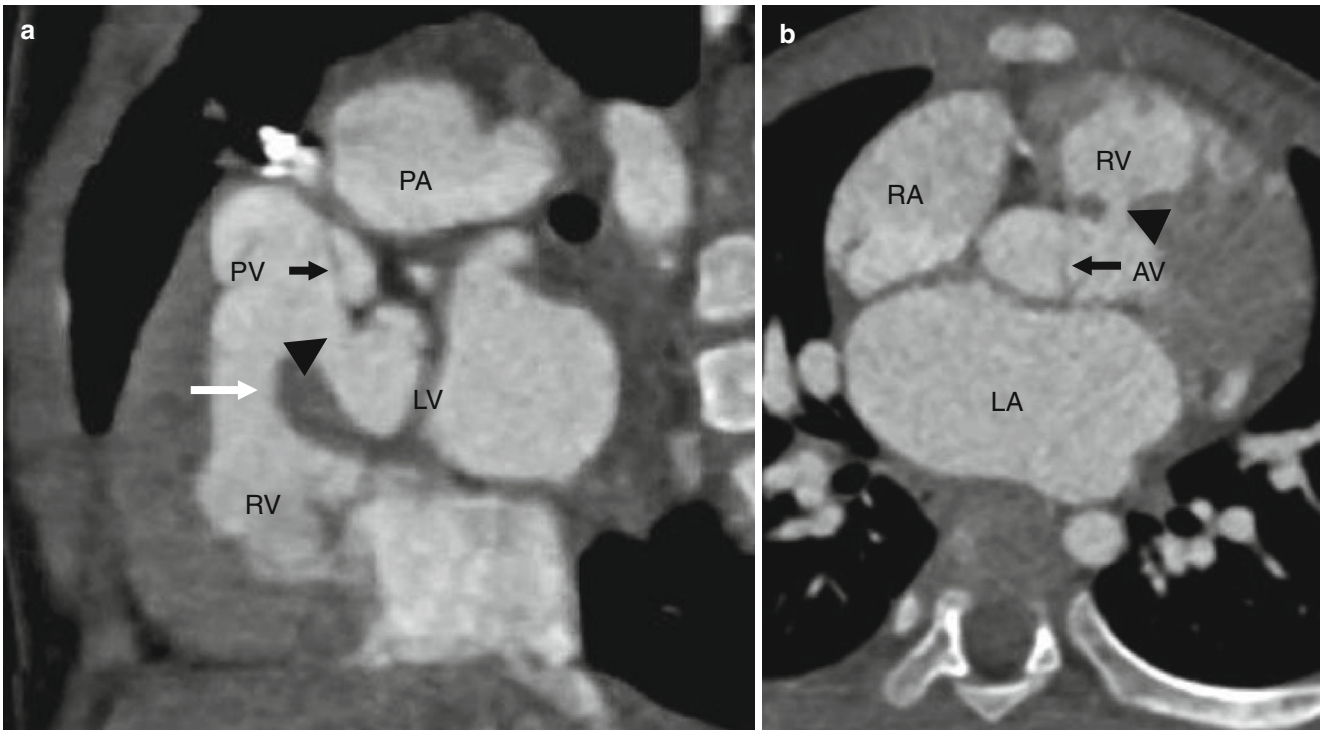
Computed tomography (CT) images of a type 1 ventricular septal defect (VSD) (synonyms: subarterial, supracristal, conal septal defect, infundibular, subpulmonary). Panel a is a sagittal picture and panel b is an axial slice. Panel a shows a communication (*black arrowhead*) that is localized underneath the pulmonary valve (*black arrow*)
